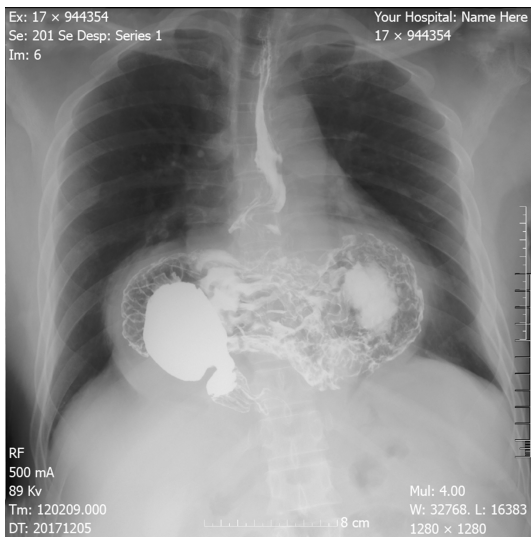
Barium contrast radiography. Confirming large hiatal hernia, and the configuration of the stomach within the hernia suggested an organoaxial volvulus.
